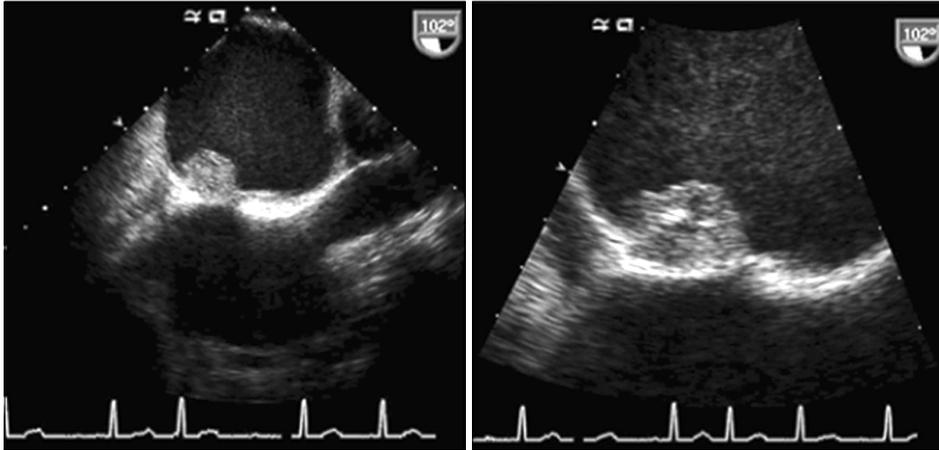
Transesophageal echocardiography showed a complex, echogenic, round mass lesion in the left atrial side of the interatrial septum.
